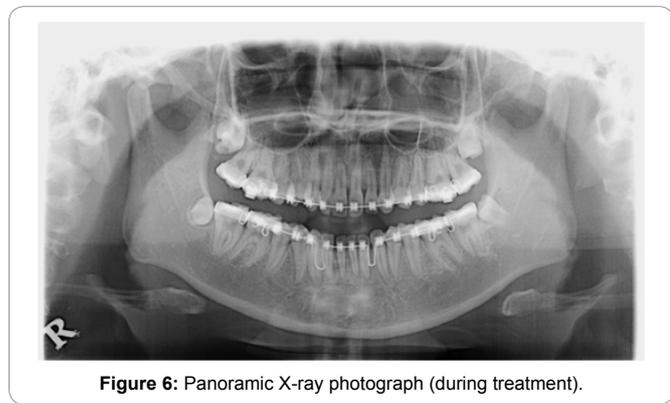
Panoramic X-ray photograph (during treatment).
